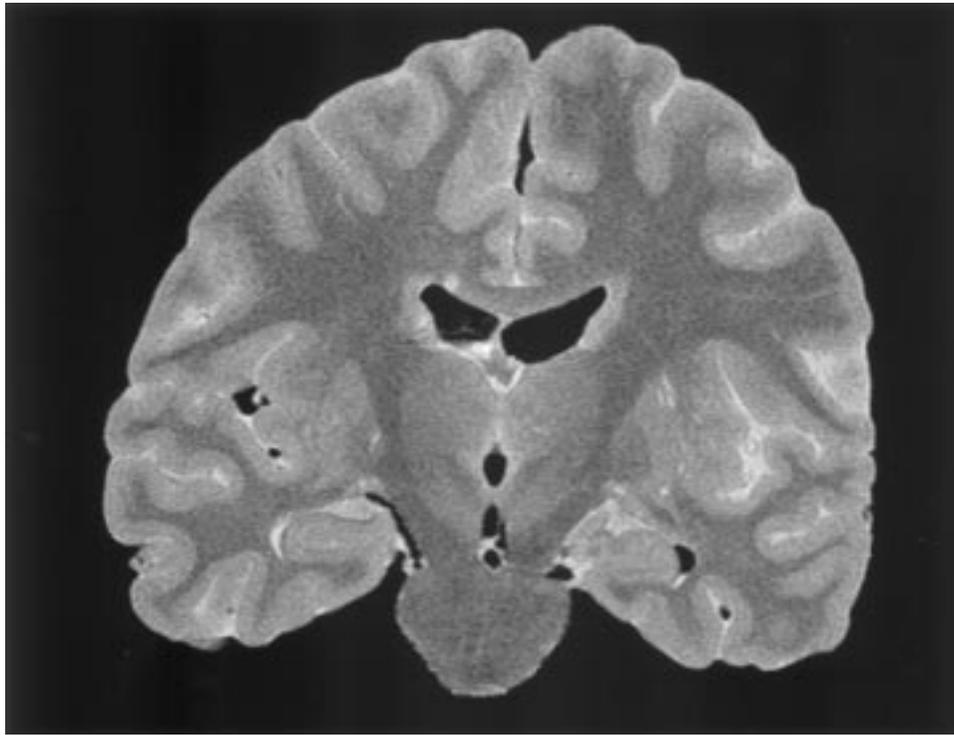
Coronal slice from a proton density-weighted MRI scan of a post-mortem brain (autistic male, age 14) displaying contrast and resolution obtained after 3 months of fixation.
